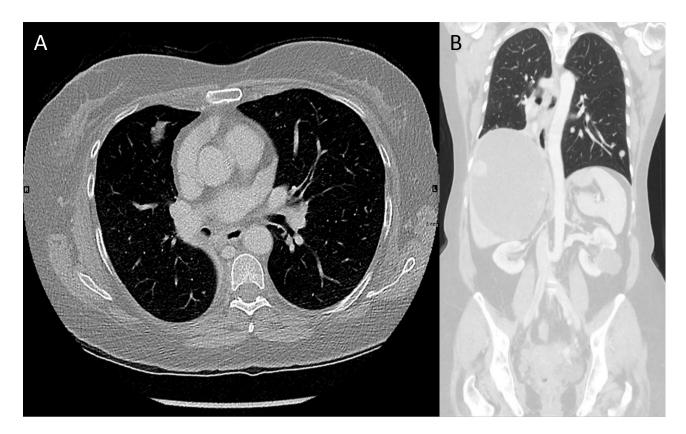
Enhanced computed tomography scan. A, (axial) demonstrating obstruction on the right lower lobe bronchus and right lower lobe collapse. B, (coronal) showing bronchus intermedius obstruction, huge hepatic cystic necrotic metastatic mass with multiple mural nodules, left renal metastasis, and heterogeneous solid uterine mass.
